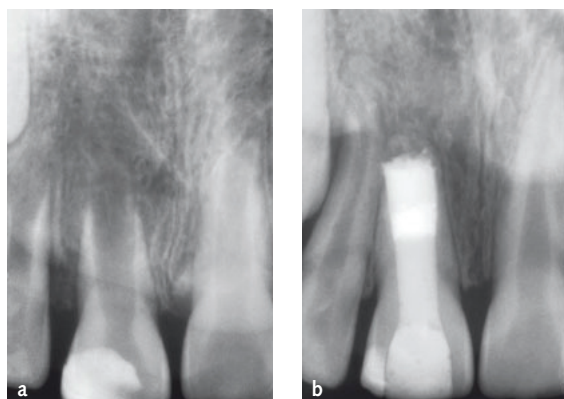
a) Preoperative radiograph of tooth 11 showing an apical translucency. b) Two-year postoperative control radiograph demonstrating a successful outcome.
